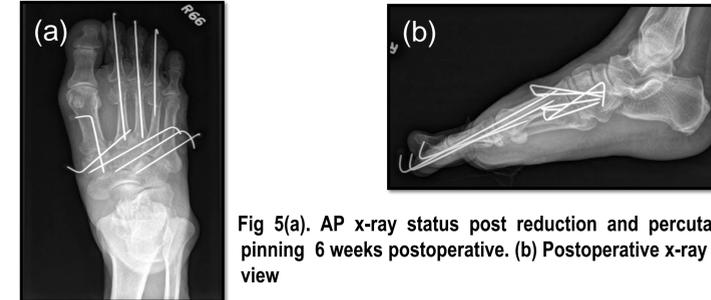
(a). AP x-ray status post reduction and percutaneous pinning 6 weeks postoperative. (b) Postoperative x-ray lateral view
